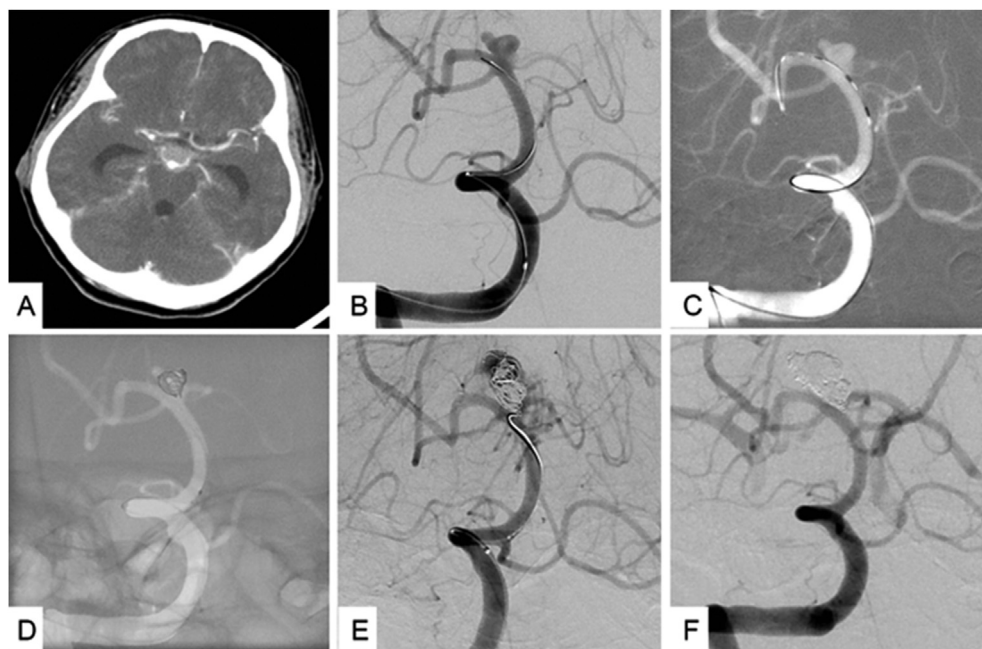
Brain CTA and DSA showed bilobular aneurysm at the top of the basilar artery with diffuse SAH (Fig. 1A,B). Stent-jailed technique for coiling with an Enterprise stent (Cordis Neurovascular, Miami Lakes, FL, USA) placement from right posterior cerebral artery to basilar artery trunk (Fig. 1C). The first coil was deployed well (Fig. 1D). Profound extravasation secondary to the dome of aneurysm torn by migration of the microcatheter while placing the second coil was found by angiography (Fig. 1E). One-year angiographic follow-up showed no recurrent aneurysm (Fig. 1F).
